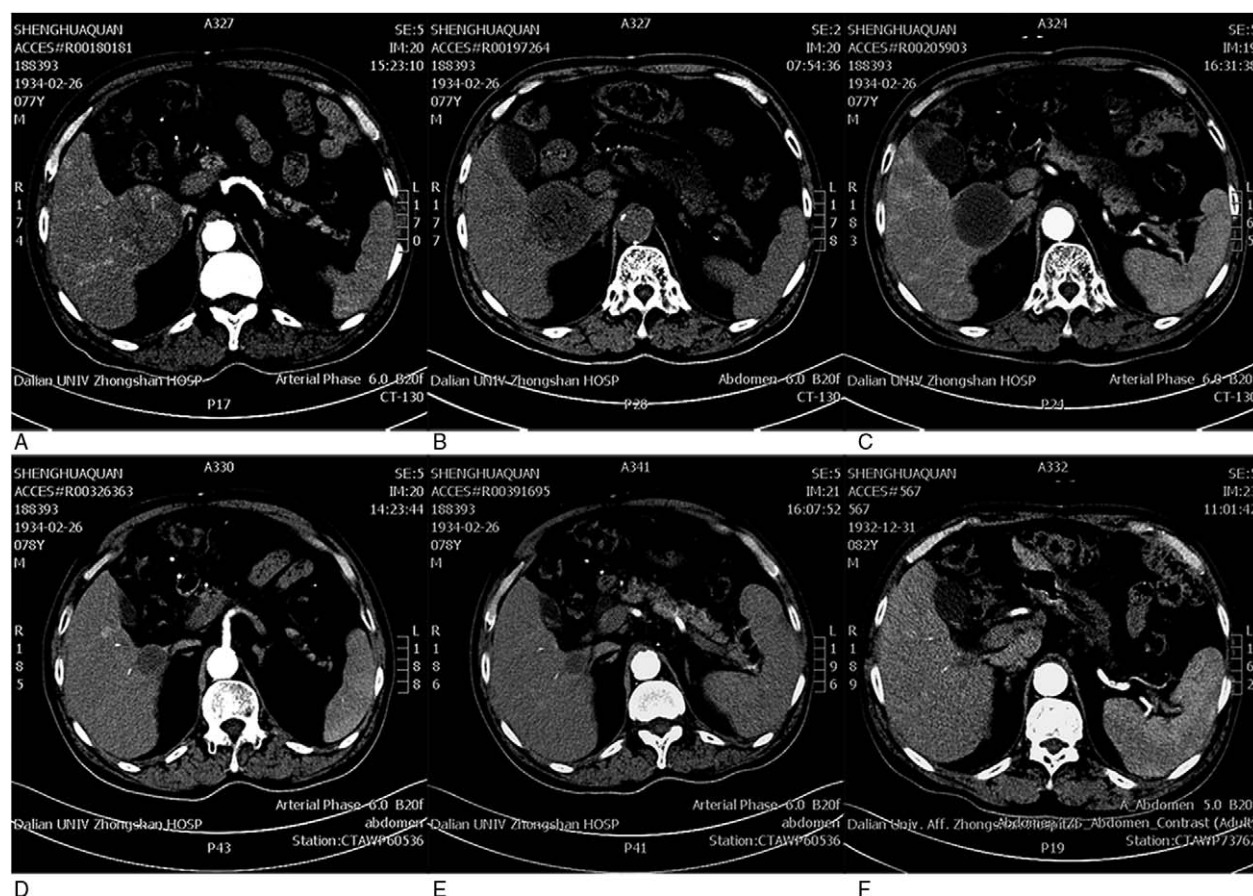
Computed tomography (CT) image of liver of a 78-year-old patient with primary liver cancer. (A) CT image of liver before surgery; (B) review CT image at 7 days after GS-TACE; (C) review CT image at 1 month after GS-TACE; (D) review CT image at 8 months after GS-TACE; (E) review CT image at 12 months after GS-TACE; (F) CT image after 3-year follow-up.
